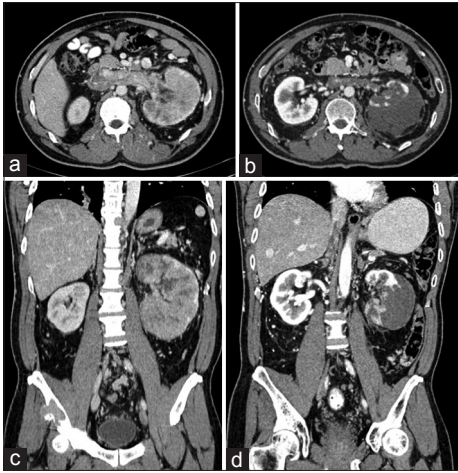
Contrast-enhanced computed tomography abdomen before (a and c) and 1 year following initiation of pazopanib (b and d)
